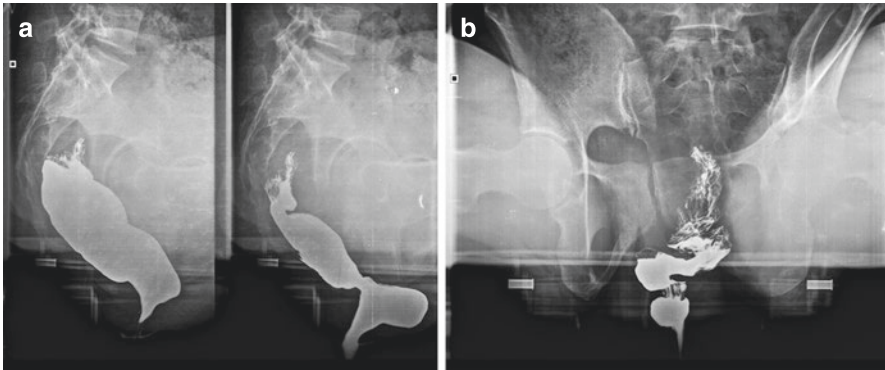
X-ray defecography in the evacuation (a) and post-evacuation phase (b). Images show the presence of an anterior rectocele with incomplete expulsion of contrast medium
